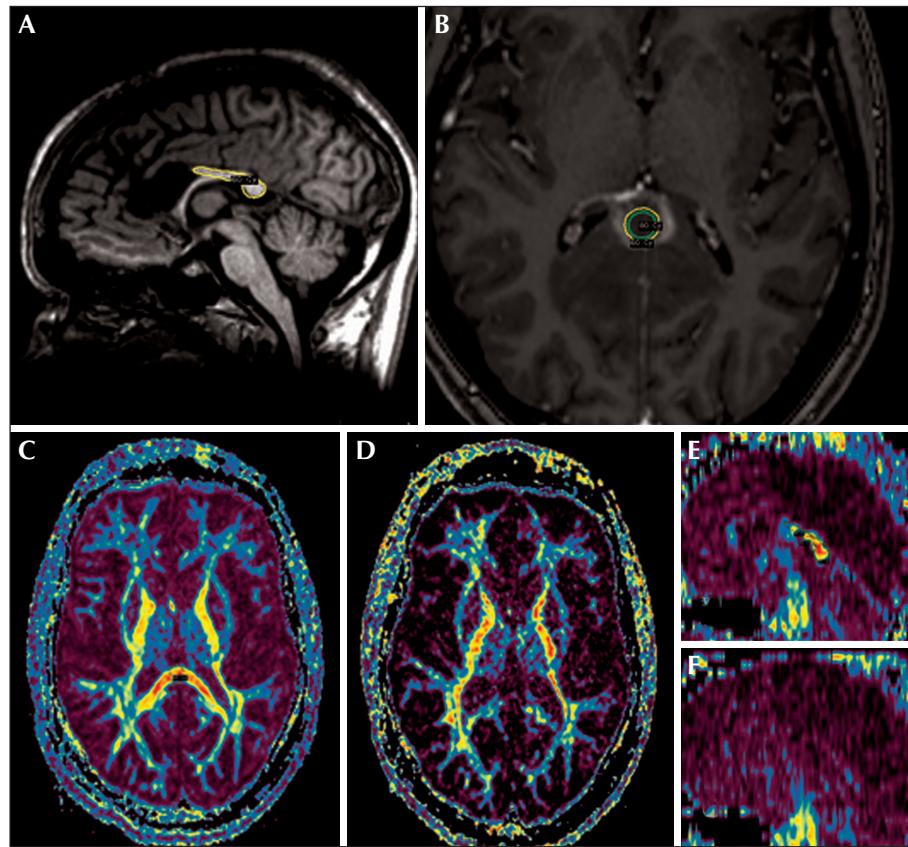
(A) Gamma knife posterior callosotomy with eight shots of 4-mm collimators and one shot of 8-mm collimators making it possible to deliver a dose of 60 Gy at 50% isodose at the level of the residual part of CC. The total volume of the prescription isodose was 1.36 cm³. (B) Axial T1-weighted image with gadolinium contrast demonstrates the enhanced signals around the isodose line. C-F) Tractography demonstrating the level of reduced corpus callosum signal relative to before GK-C (C, E) and after GK-C (D, F).
